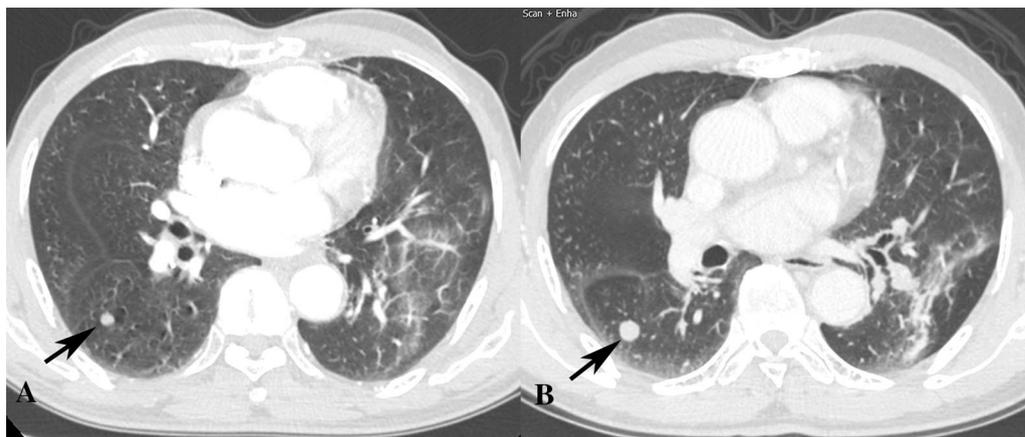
The transaxial lung window CT of 1 year after surgery (A) showing pulmonary metastasis. The largest node's diameter is 0.6 cm in the right lower lobe nodule (A, arrow). The nodules increased during the next 3 years of follow-up. The largest node's diameter is 1.1 cm (B, arrow).
